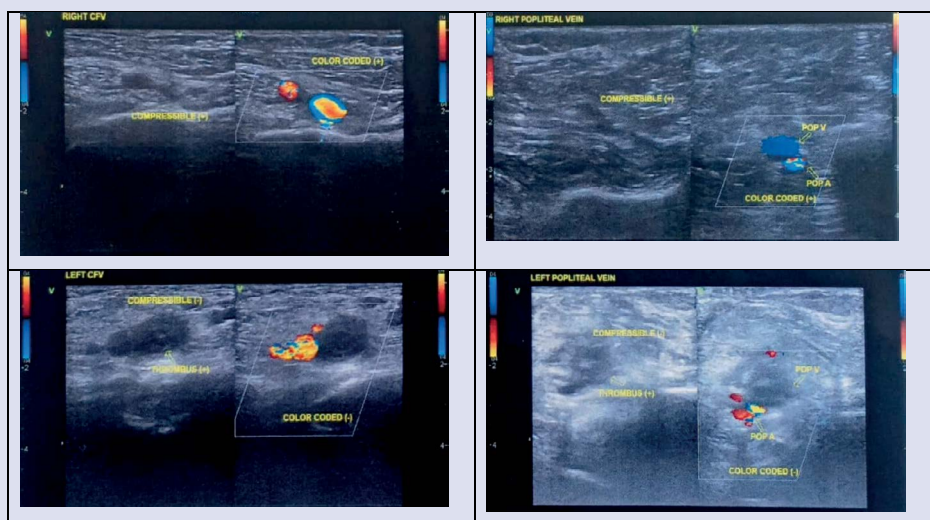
Lower Extremity Venous Ultrasound Doppler, Showed Thrombuses on The Left Femoral and Popliteal Vein.
